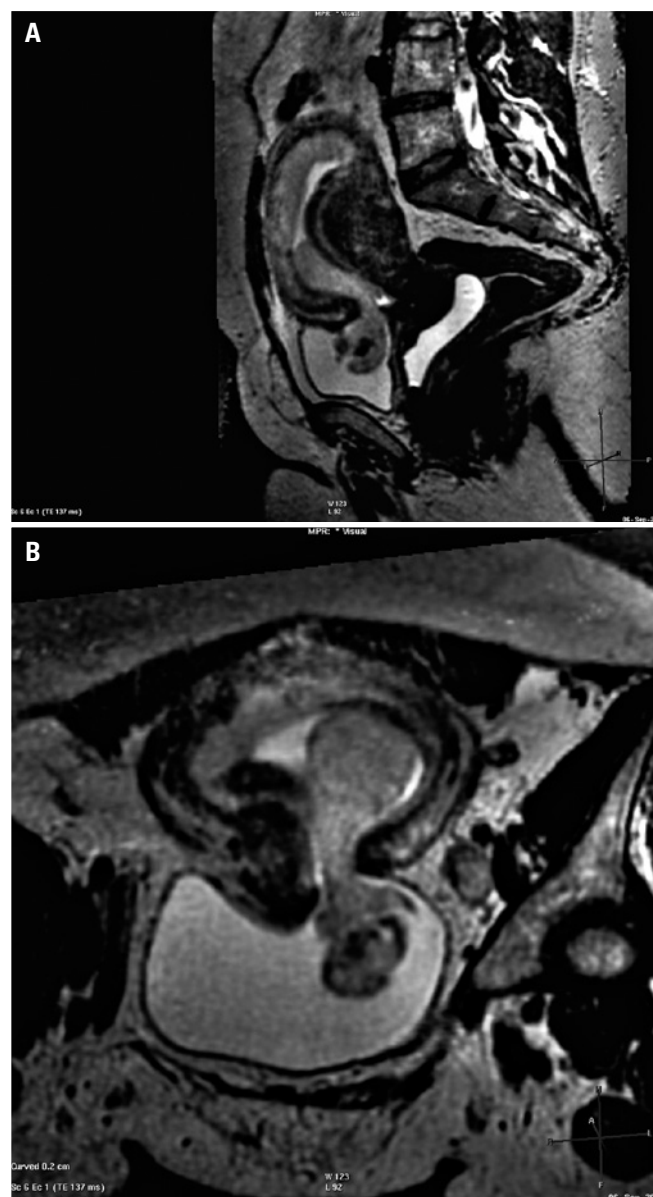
A and B. Magnetic resonance imaging showing fetus partially within the maternal bladder
